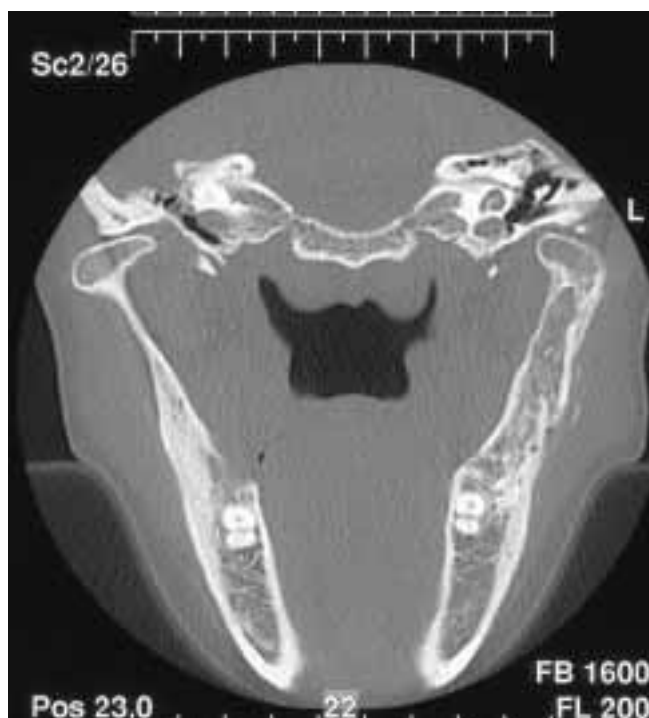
One year controlling CT-scan section
